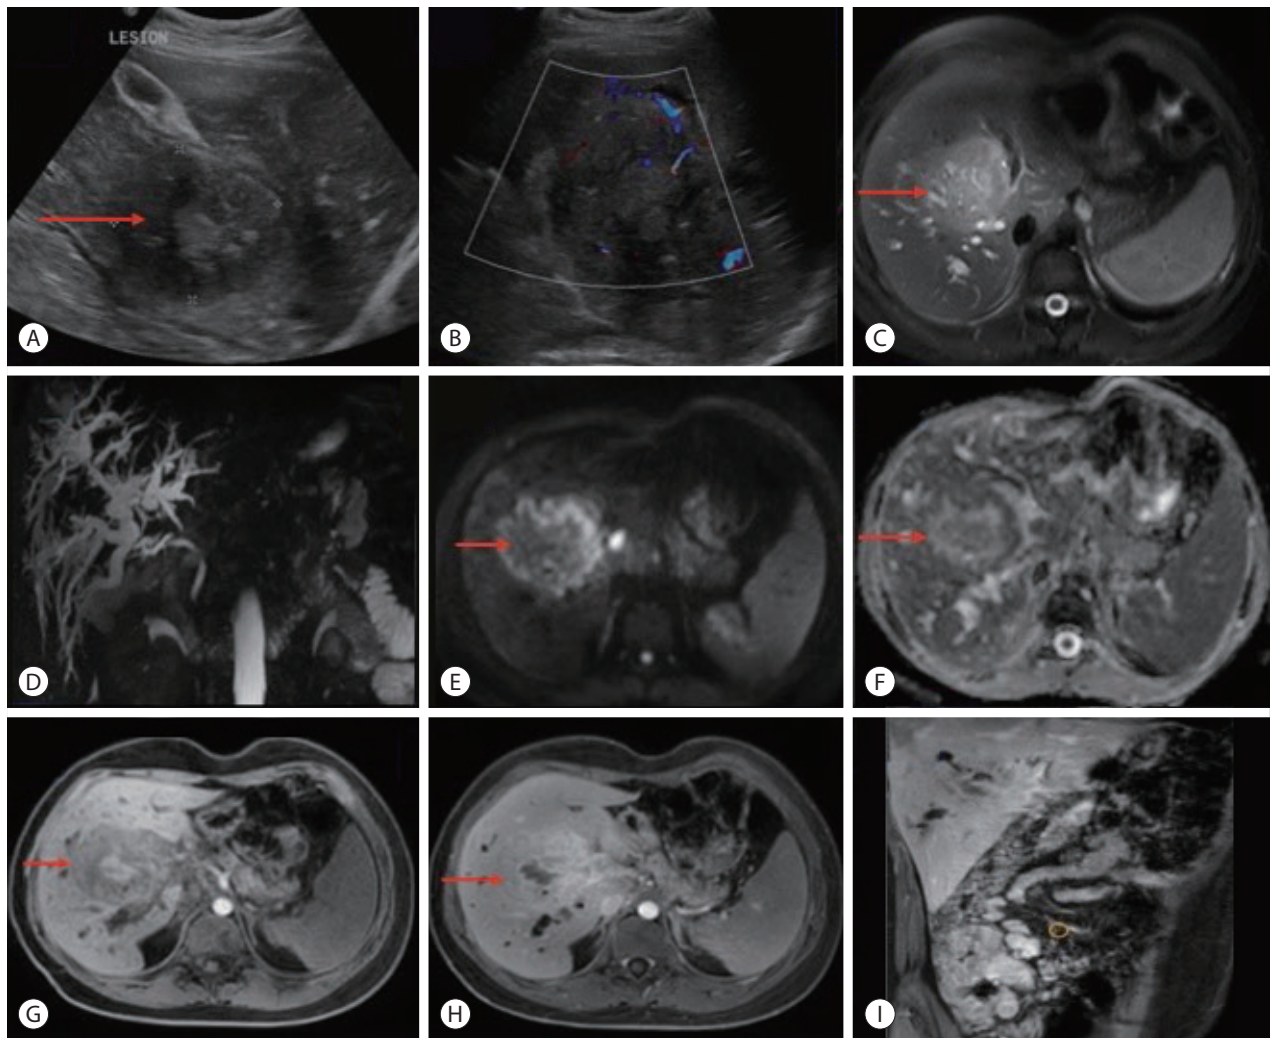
(A) An ultrasonography image shows a large hypoechoic lesion measuring 6.7×6.1 cm in the region of portal confluence involving segments 5, 6, and 7 of the liver (red arrow). (B) Color doppler reveals mild color flow within the lesion. (C) Transverse relaxation time fat-saturation magnetic resonance imaging of the liver demonstrates heterogeneously hyperintense signal intensity lesion (red arrow). (D) Magnetic resonance cholangiopancreatography sequence shows the mass effect with markedly dilated intrahepatic biliary radicles. (E, F) Diffusion-weighted imaging and corresponding ADC images show areas of diffusion restriction with low ADC in and around the lesion involving the right lobe of the liver (red arrows). On (G) pre- and (H) post-contrast mDIXON (T1W) studies, heterogeneous enhancement with few central non-enhancing areas was seen within the lesion (red arrows). These findings were suggestive of hilar cholangiocarcinoma. (I) Coronal post-contrast mDIXON images show thickening with an enhancement of the cecum, ascending colon, and heterogeneously enhancing lesion in the liver. ADC, apparent diffusion coefficient.
